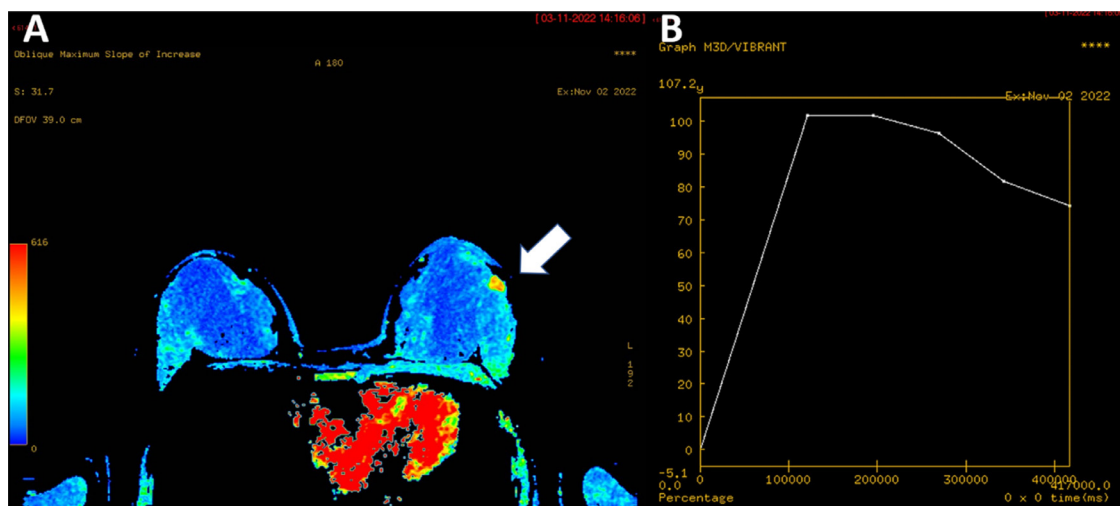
Lesion (arrow) showed a quick initial increase on dynamic T1-weighted imaging with contrast enhancement (A), followed by a wash-out in the delayed phase (B).
